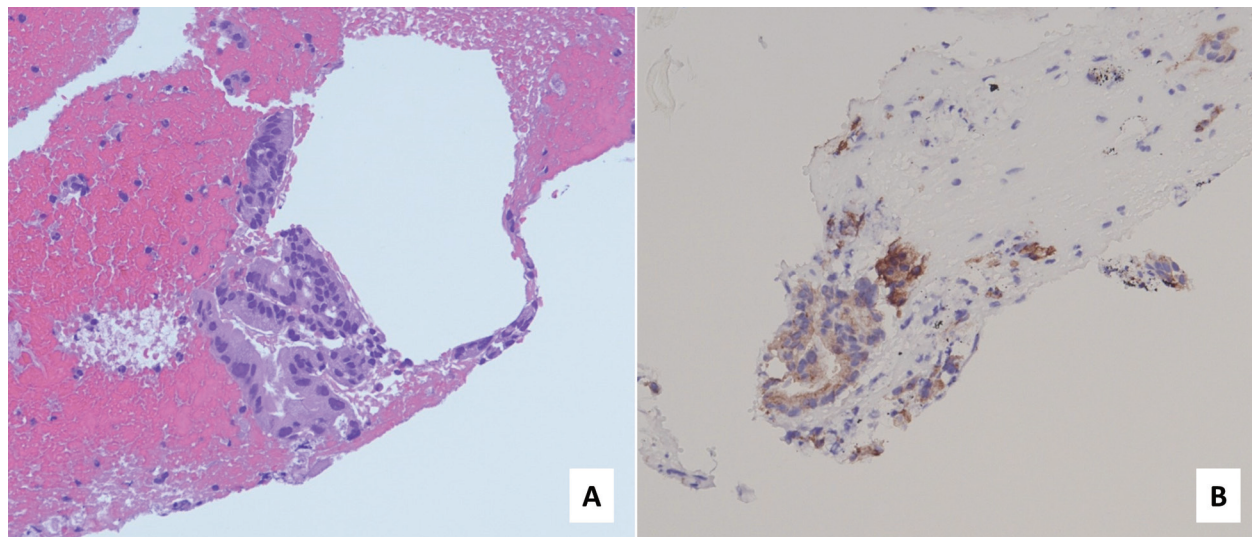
Endobronchial ultrasound-guided transbronchial biopsy pathology findings.
